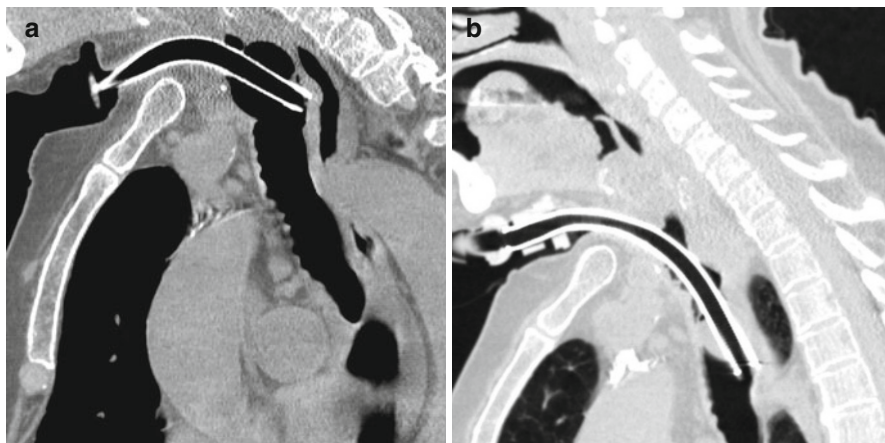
Inappropriate tracheostomy tube occluded against the posterior tracheal wall. (a) Computed tomography scan of the neck and chest, sagittal plane. The distal end of the tracheostomy tube lies against the membranous tracheal wall, in the upper third of the trachea, and oriented posteriorly. (b) A new tracheostomy tube with different characteristics has been positioned. The distal opening of the new tube appears more patent compared with the previous tube
